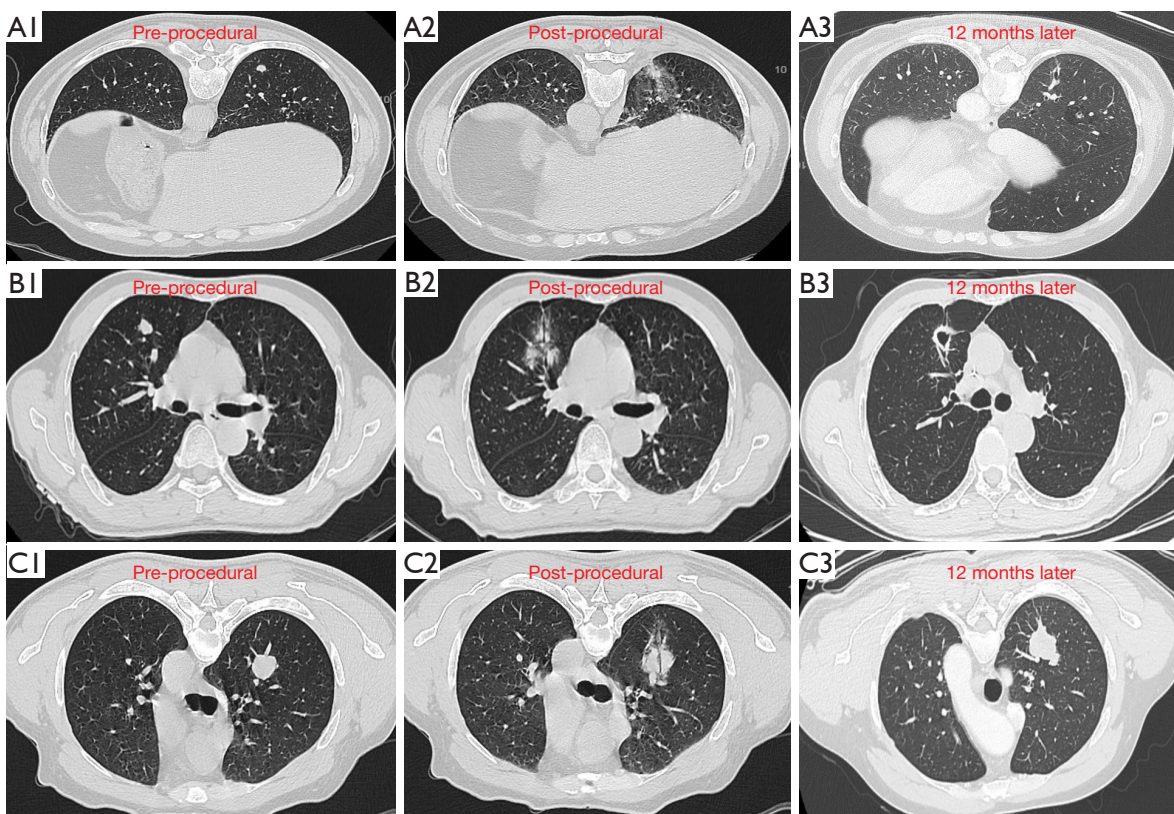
CT features of CR, ICR, PD. (A) CT features of CR: (A1) tumor lesion of CR (pre-ablation); (A2) HU of the ablation zone decrease significantly; (A3) the ablation zone form fibrosis and cavity. (B) CT features of ICR: (B1) tumor lesion of ICR (pre-ablation); (B2) HU decrease of the ablation zone is not significant; (B3) residual lesions can be observed surrounding the ablation zone. (C) CT features of PD: (C1) tumor lesion of PD (pre-ablation); (C2) HU of the ablation zone increase significantly; (C3) local tumor progression was observed during follow-up. CR, complete response; ICR, incomplete response; PD, progressive disease; CT, computed tomography; HU, Hounsfield unit.
